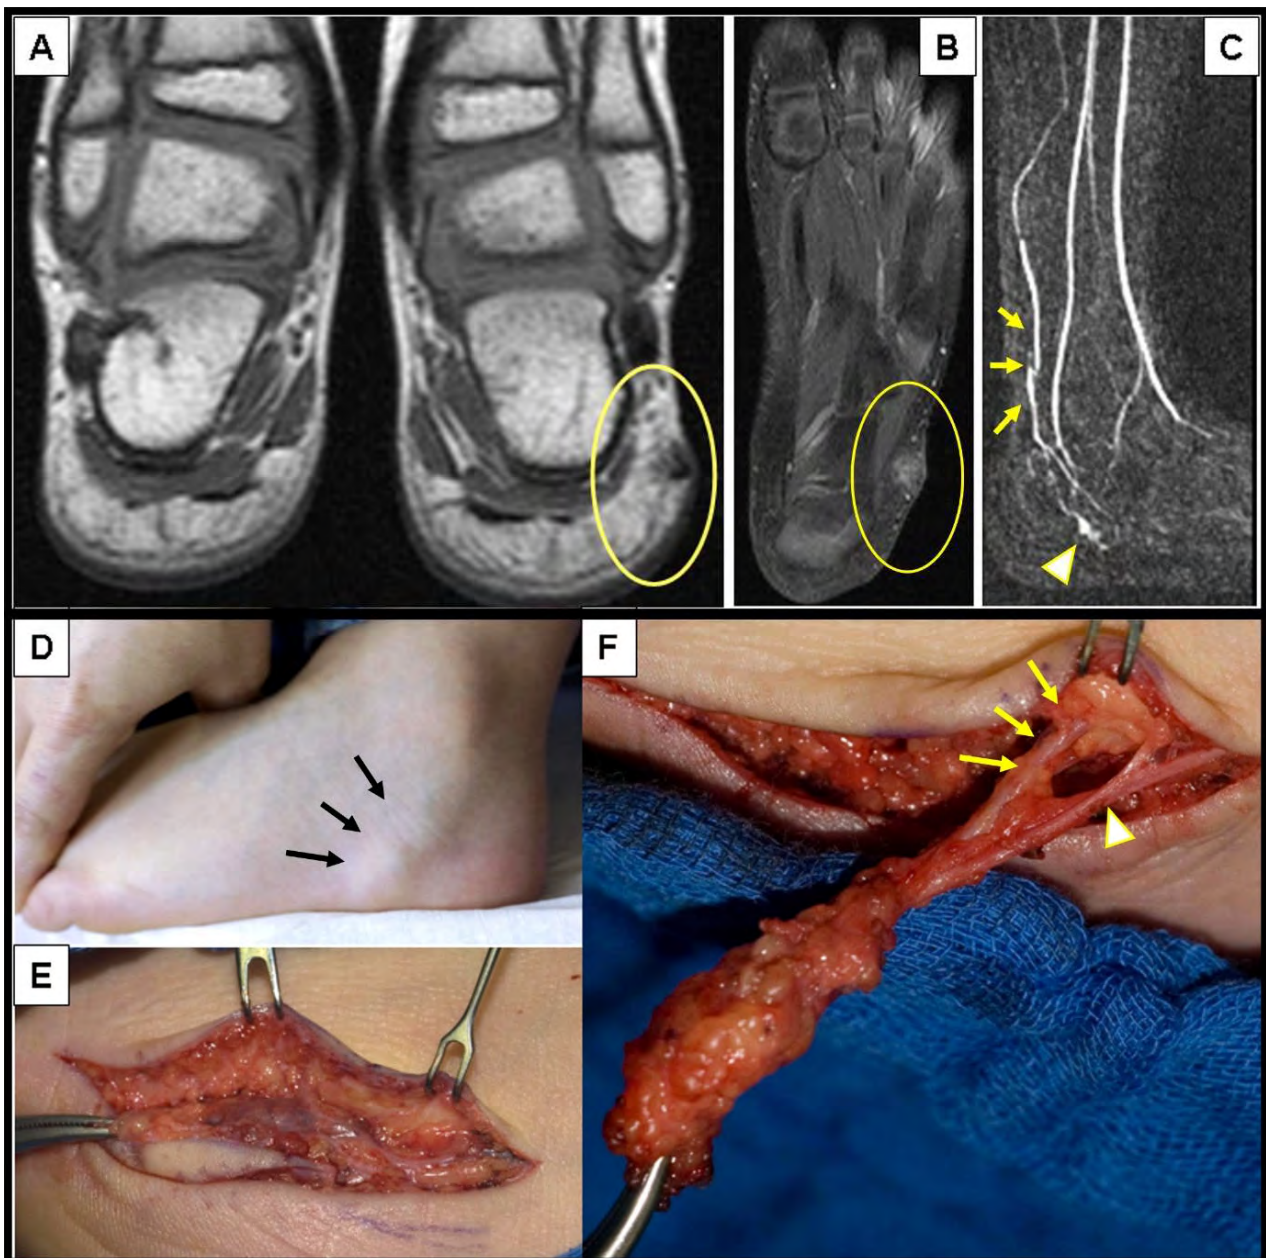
A 3-year-old boy with a pulsatile lesion under the malleolus lateralis of the left foot (D)—(black arrows). MRI showed a localized arterio-venous malformation in the subcutaneous tissue (A,B) with an AV shunt in the MR-angiography (C)—(arrowhead) depicted by the early visualization of the vein (C)—(yellow arrows). Complete surgical excision was performed (E) with ligation of the feeding artery (F)—(yellow arrows) and the draining veins (F)—(arrowhead).
